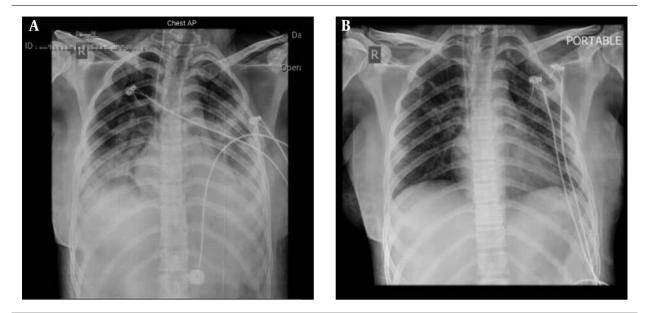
Comparison of chest radiography of the case 1; A, In the first; B, and last days of the treatment
